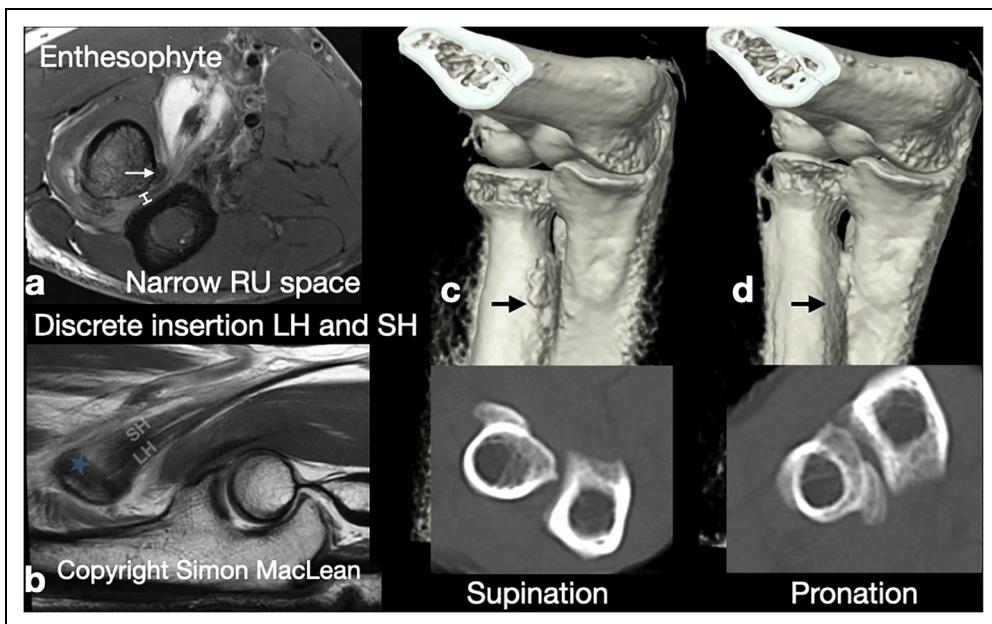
Anatomical factors associated with partial distal biceps tendon tears. (a) Axial MRI slice showing an enthesophyte on the radial tuberosity with a narrow radioulnar space. (b) Sagittal MRI slice showing discrete insertions of the long and short head with a short head tear (blue asterisk). (c, d) Dynamic 4D CT images with axial equivalents showing significant narrowing of the radioulnar space in pronation from supination (radial tuberosity – black arrow). Copyright Mr Simon MacLean. MRI: magnetic resonance imaging.
